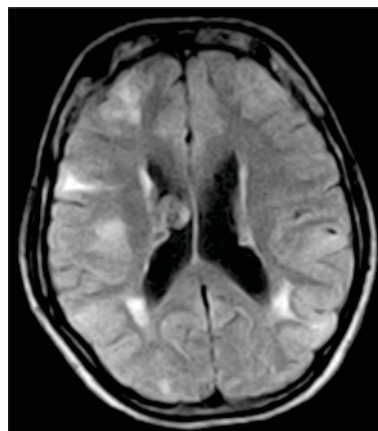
MRI, Axial FLAIR image showing cortical and subcortical tubers in right frontal lobe and bilateral parietal lobes.
